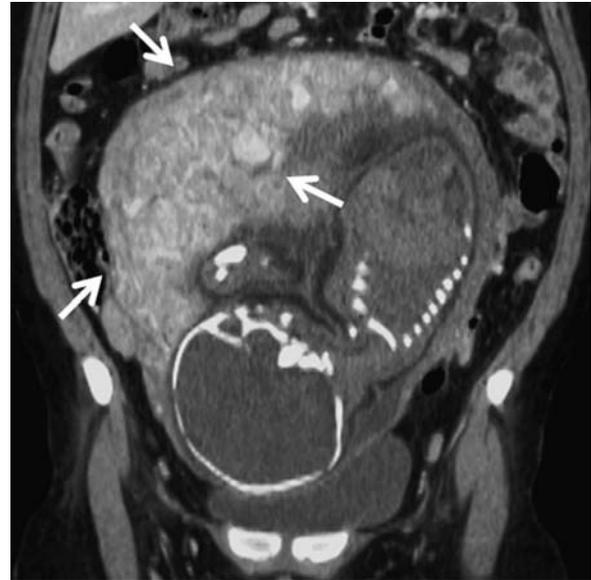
Normal computed tomographic appearance of the placenta at 39-week gestation. Coronal contrast-enhanced computed tomographic image obtained after maternal trauma shows expected relatively marked heterogeneous enhancement of the placental tissue (arrows), given the stage of the gestation. There is no evidence of maternal, placental, or fetal injury.
